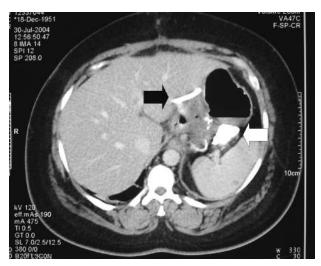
Computed tomography scans can be used not only to diagnose leaks, but also to differentiate between localized and diffuse intra-abdominal collections. The white arrow points to a localized collection of contrast material outside the bypassed stomach, suggestive of an anastomotic leak. The black arrow points to the surgically placed drain that in this case is not in contact with the collection.
